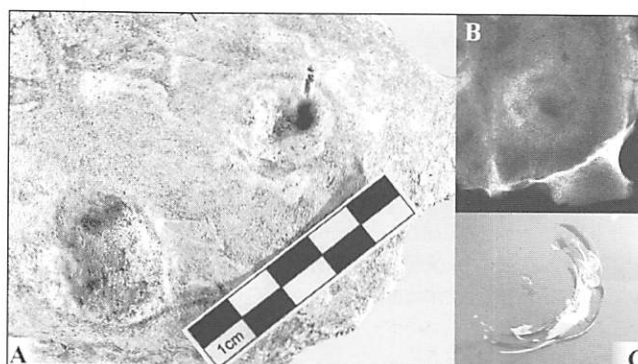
T 108. A) Macroscopic aspect; B) Radiographic analysis C) Car glass fracture pattern.
